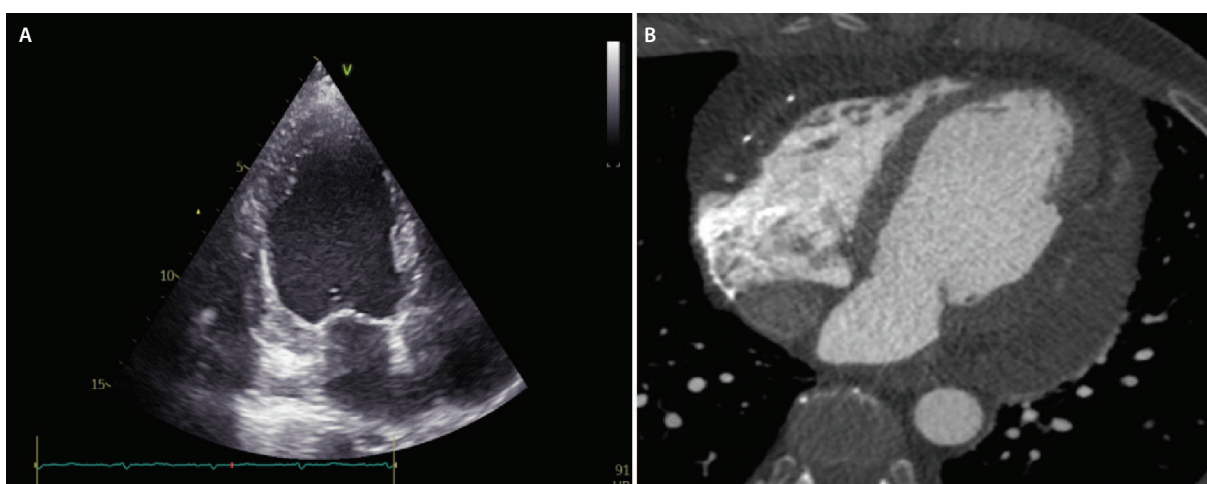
A) Postoperative transthoracic echocardiogram: the two chamber view showing the basal lateral wall patch; B) postoperative computed tomography: no residual wall microdefects.
